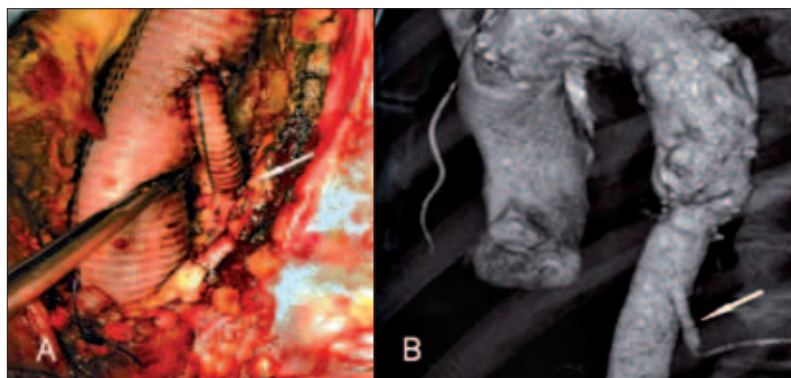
Surgical picture (A) and postoperative CT (B) showing critical intercostal artery reimplantation (arrow) to the aortic graft by means of single Dacron bypass.
